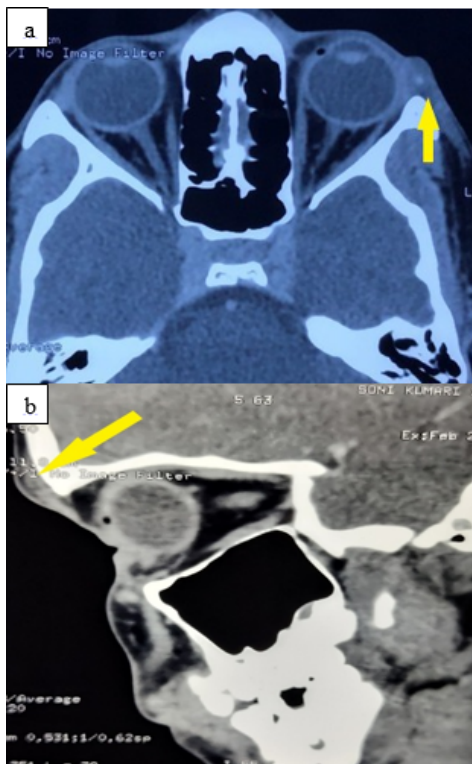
a & b: CT scan image showing an isointense lesion with illdefined margin in anterior part of LE lateral orbital wall
